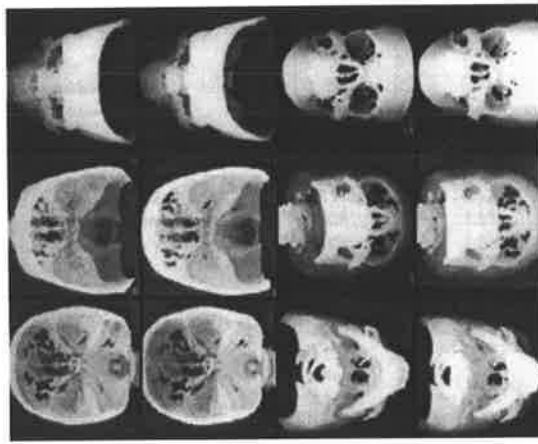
Stereo images of a 3D CT reconstruction of an adult patient with Treacher Collins Syndrome used for determination of osseous landmarks for rotations about the X-axis of [27°, 36°], [72°, 81°], [117°, 126°], [225°, 234°], [270°, 279°] and [315°, 324°] in order down the left pair of columns and up the right pair.
